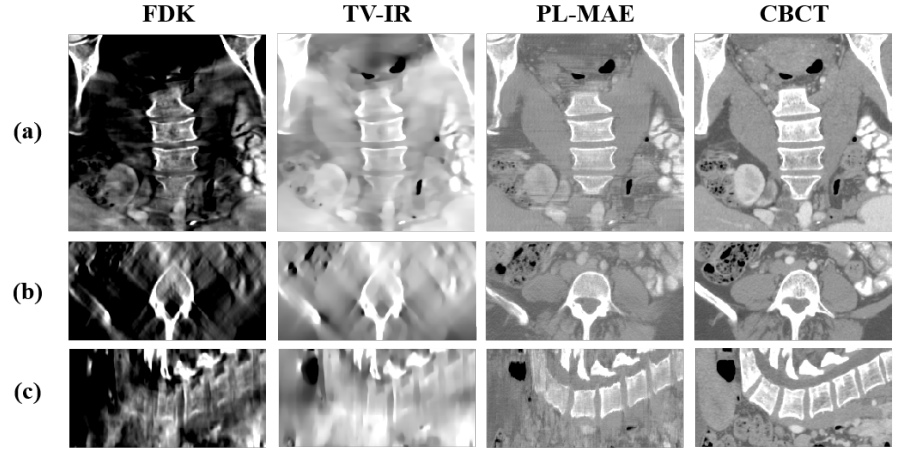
Results with clinical data. NIH chest images reconstructed with FDK and TV-IR, deblurred images by the proposed method with PL-MAE loss function, and CBCT images (from left to right) for (a) axial, (b) coronal, and (c) sagittal planes. The display window is $[-450\ 450]$ in Hounsfield unit (HU).
